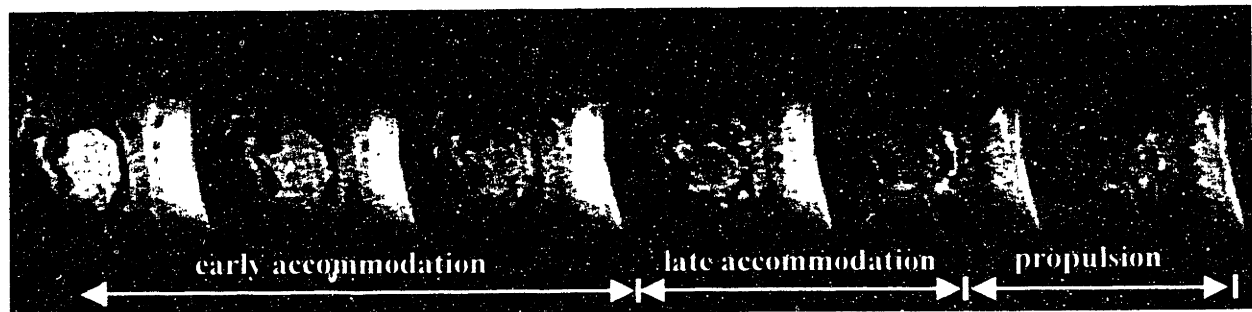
A sequence of mid-sagittal images of tongue deformation acquired at 10 Hz using a HASTE MRI pulse sequence depicts early accommodation, late accommodation, and propulsion. The subject is swallowing a 10ml bolus of water.
